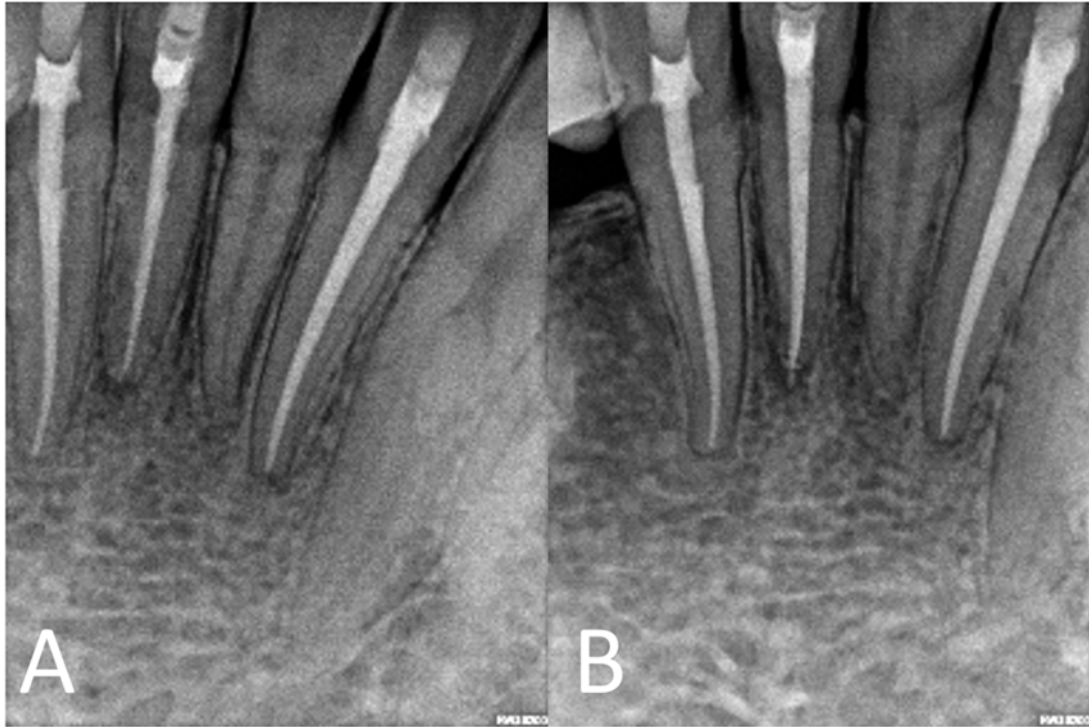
A. Radiographic presentation of the mandibular incisors at the 18-month follow-up visit. B. Non-surgical retreatment was initiated on the mandibular right central incisor due to the continued presence of periapical pathosis.
